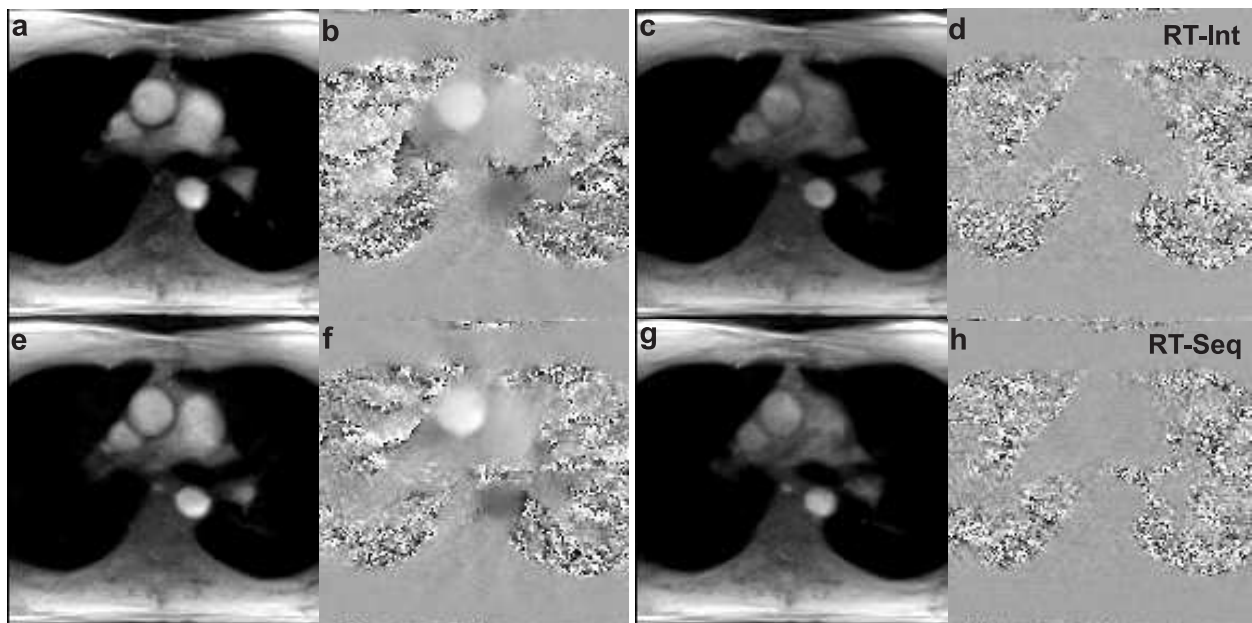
Transverse view of the human heart at the region of ascending aorta: magnitude images (a, c, e, g) and phase-contrast maps (b, d, f, h) during peak systole (a, b, e, f) and diastole (c, d, g, h) phase of the cardiac cycle obtained for sequential (RT-Seq) and interleaved (RT-Int) acquisition schemes of the real-time PC MRI.
